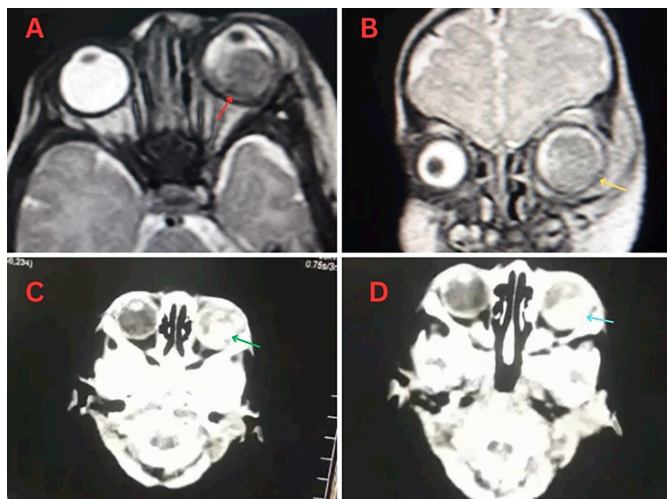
(A, B) MRI of a 2-month child showing hypo-intense retinal-based mass (red arrow) and scleral involvement at the 4 o'clock position (yellow arrow). (C, D) Show the CT scan of the same child with dense calcifications in the vitreous cavity (green arrows).
